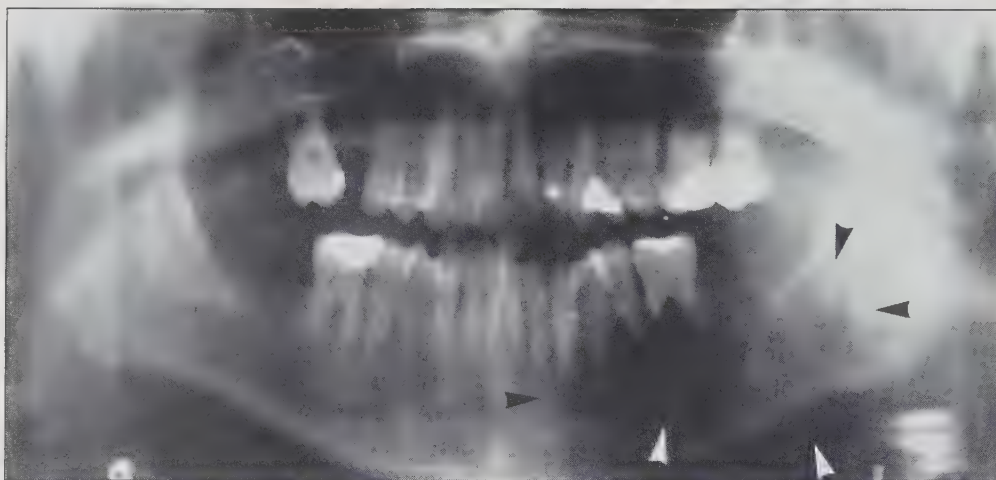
(Case 3): A 26-year-old male presented with an extensive ameloblastoma involving both hard and soft tissues. Panoramic radiograph exhibiting a large multilocular radiolucency extending from the parasymphysis to the vertical ramus (white and black arrows). Note prominent root resorption and inferior border involvement.
